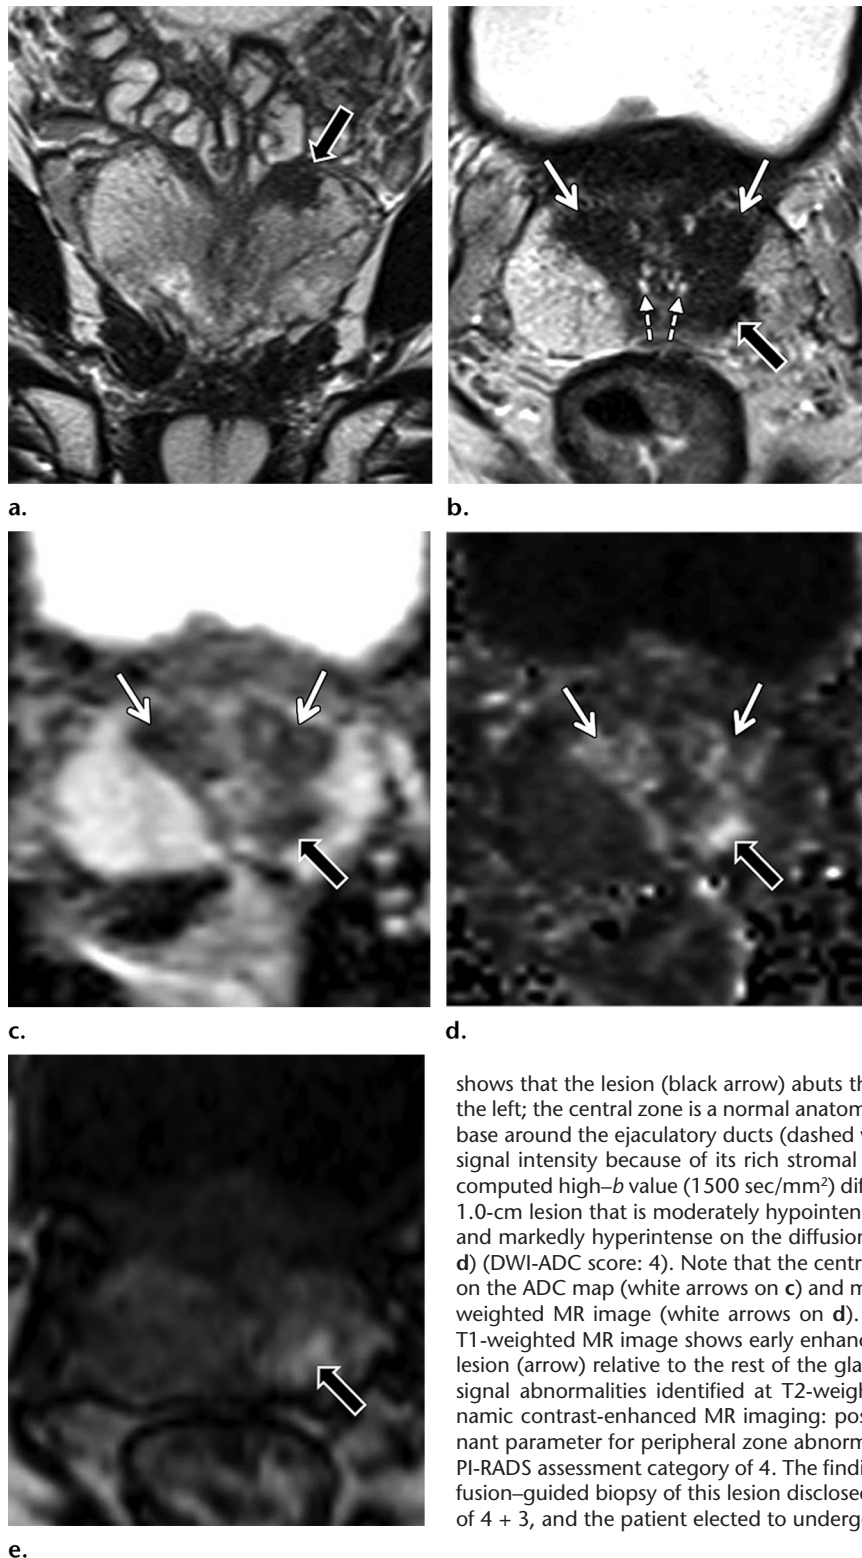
Images of a 70-year-old man with prostate cancer (Gleason score, 3 + 3) detected at systematic transrectal US-guided biopsy, who was referred for multiparametric MR imaging before entering a program of active surveillance of the cancer. (a) Coronal T2-weighted MR image shows a hypointense focal nodular lesion (arrow) in the left posteromedial peripheral zone at the base (T2-weighted imaging score: 4). (b) Axial T2-weighted MR image
